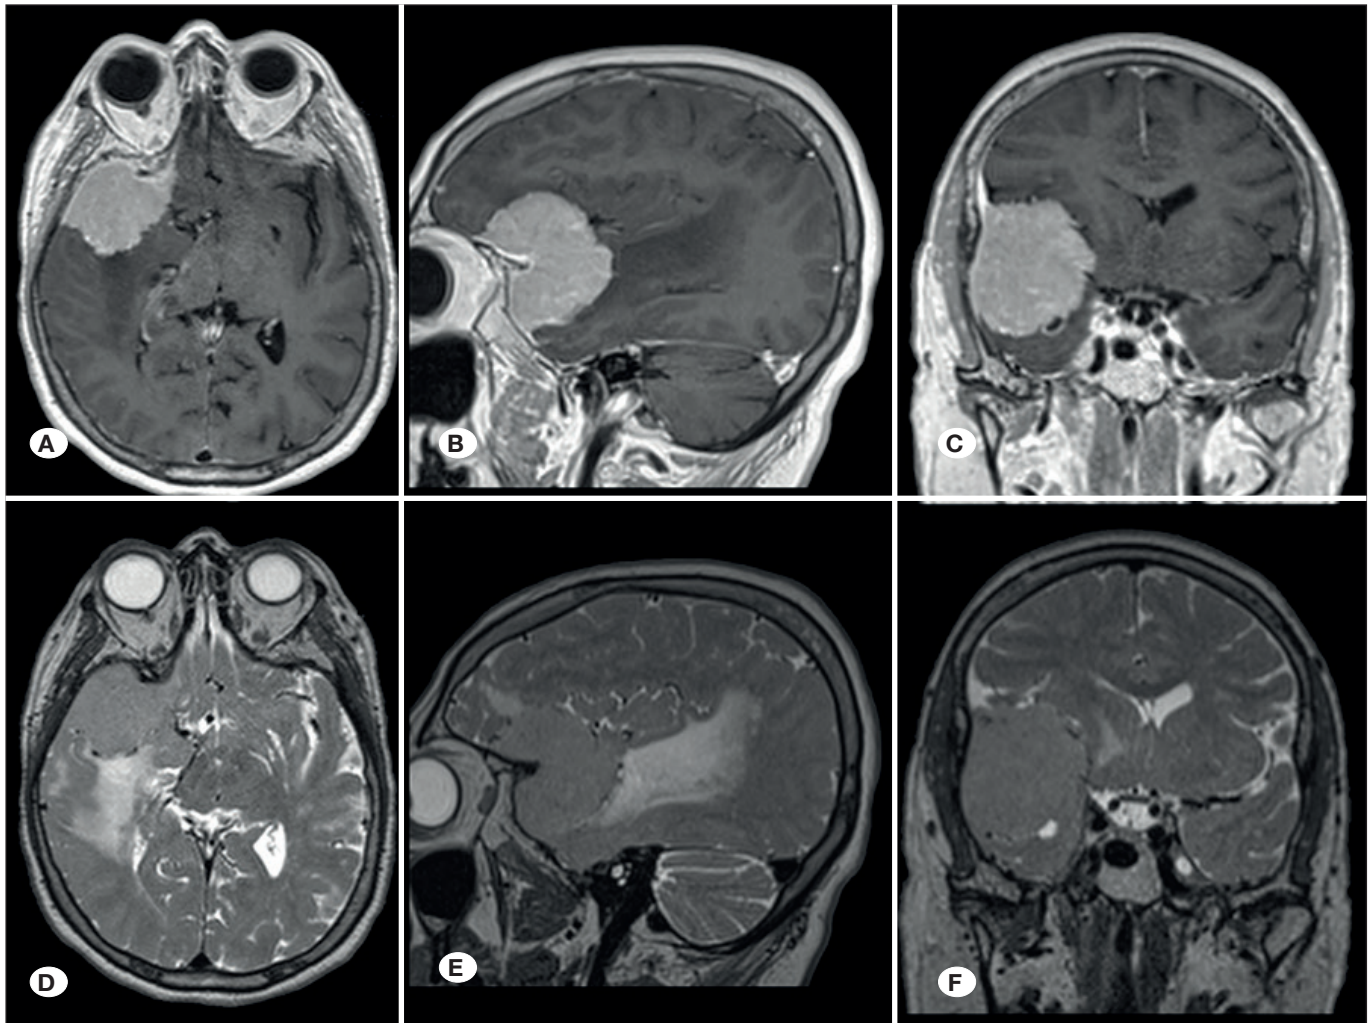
Preoperative MRI showing the presence of a meningioma in the sphenoid wing. A) Contrast-enhanced axial section. B) Contrast-enhanced sagittal section. C) Contrast-enhanced coronal section. D) T2-weighted axial segment. E) T2-weighted sagittal section. F) T2-weighted coronal section. MRI: Magnetic resonance imaging.
